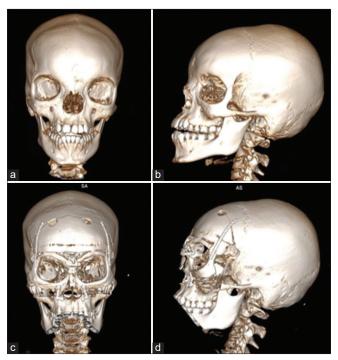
(a-b) Pre- and (c-d) 6-day postoperative cranial CT scan of patient 1.
